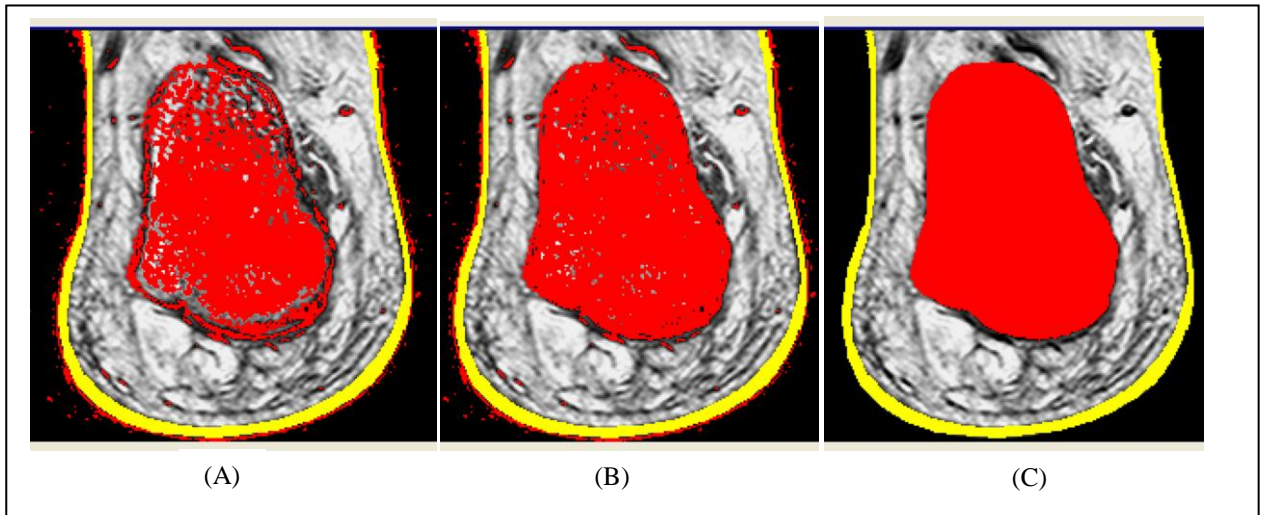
Using different algorithm for the stiff tissue segmentation: (A) Confidence connected region growing based segmentation; (B) Using floodfill tool to fill the cavities; (C) Using the Paint tool to refine the MR image.
